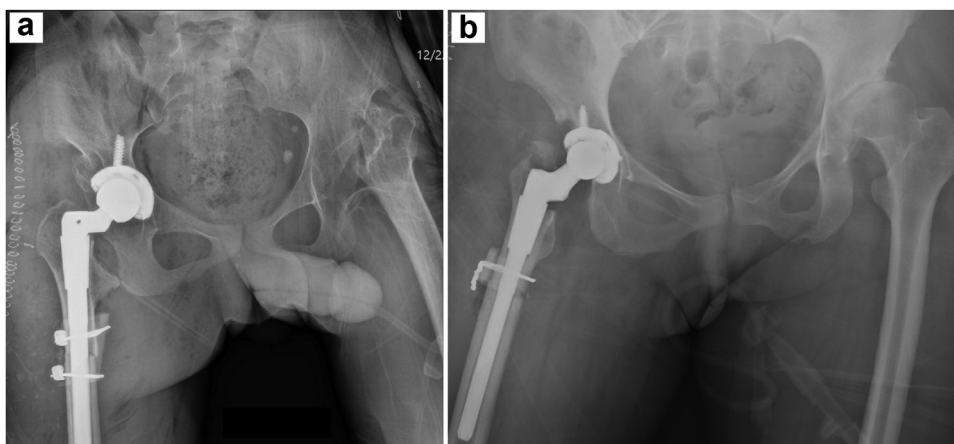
Immediate postoperative anteroposterior pelvis radiograph from (a) example patient #1 and (b) example patient #2.
